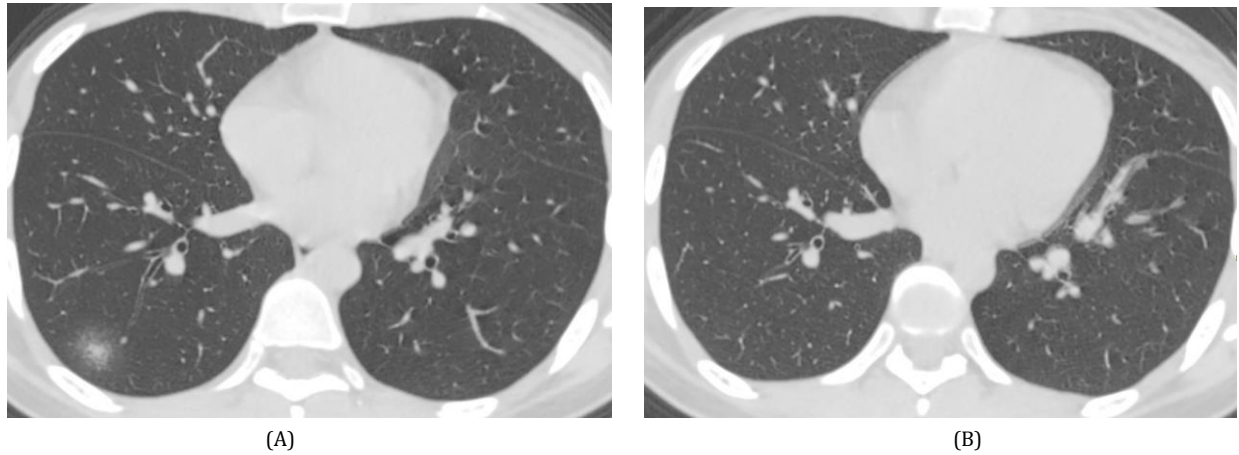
A 24-year-old female patient COVID-19. The first computed tomography scan showed mixed GGO with very few solid areas (A). After 10 days, the lesions disappeared (B).
